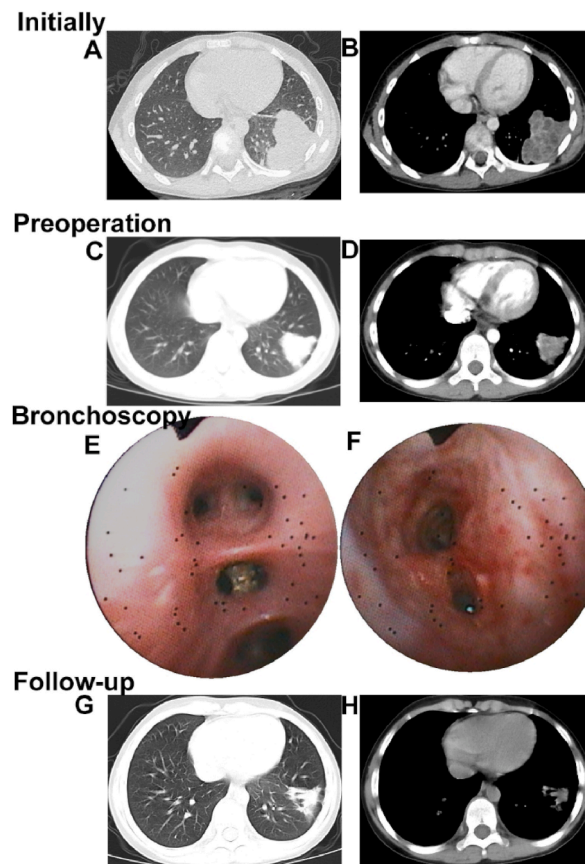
Parenchymal view (A) and mediastinal view (B) of initial chest contrast-enhanced computed tomography (CT) scan showing a thick-walled multiloculated lesion with smooth inner border and homogeneous central low density in the left lower lobe. Parenchymal view (C) and mediastinal view (D) of chest contrast-enhanced CT scan after antibiotic therapy revealing irregular patchy shadow in the lateral segment of the left lower lobe without any septa and multicystic cavities. (E) Flexible bronchoscopy showing half a peanut lodged in the lateral basal segment of left lower lobe. (F) The aspect after foreign body removal. Parenchymal view (G) and mediastinal view (H) of follow-up chest CT scan after foreign body removal showing further resolution of the lesion and residual localized bronchiectasis in it.
